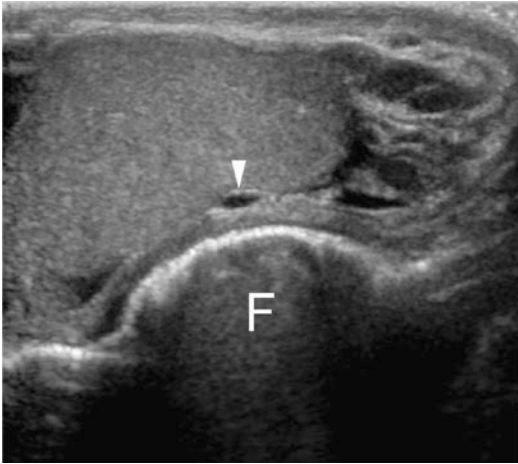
Very small cyst of the tunica albuginea. Patient presented with a small palpable testicular lesion which was not initially identified on ultrasonography. Repeated investigation combined with palpation allows immediate identification of the palpable lesion which is characterized as a small cyst of the tunica albuginea (*arrowhead*). *F* finger of the sonologist
